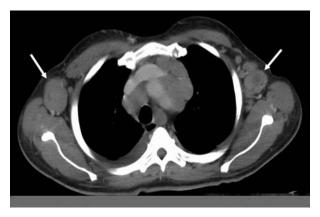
Chest computed tomographic scan of the case 1 patient demonstrates bulky axillary lymphadenopathy.
